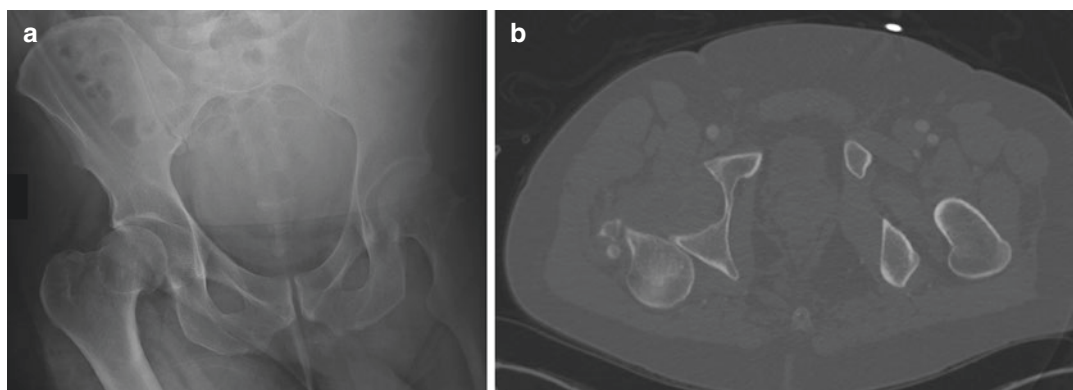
(a) AP radiograph of a posterior hip dislocation at presentation. (b) CT scan of the same case, showing the femoral head locked behind the posterior acetabulum
